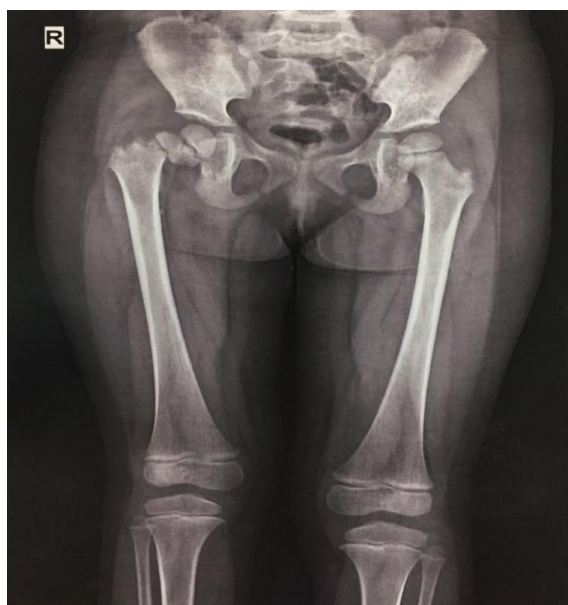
Initial radiography (before operation).
